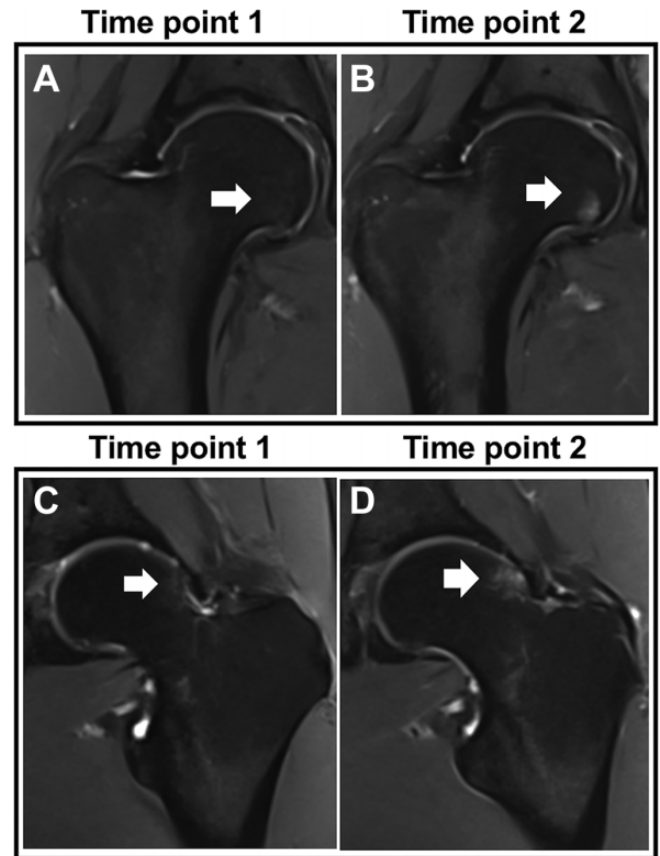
Coronal Dixon magnetic resonance imaging scans of 2 participants showing all subchondral bone marrow edema changes after the marathon. (A, B) Participant 1 had no edema before the marathon (A; arrow) and mild edema appeared after the marathon (B; grade 2, 0.5-1.5 cm; arrows). (C, D) Participant 2 had little edema before the marathon (C; grade 1, ≤ 0.5 cm; arrow), but the edema slightly extended after the marathon (D; grade 2, >0.5 - ≤ 1.5 cm; arrows). In both cases, edema changes were seen in the nonweightbearing area and likely due to impingement and not running.
